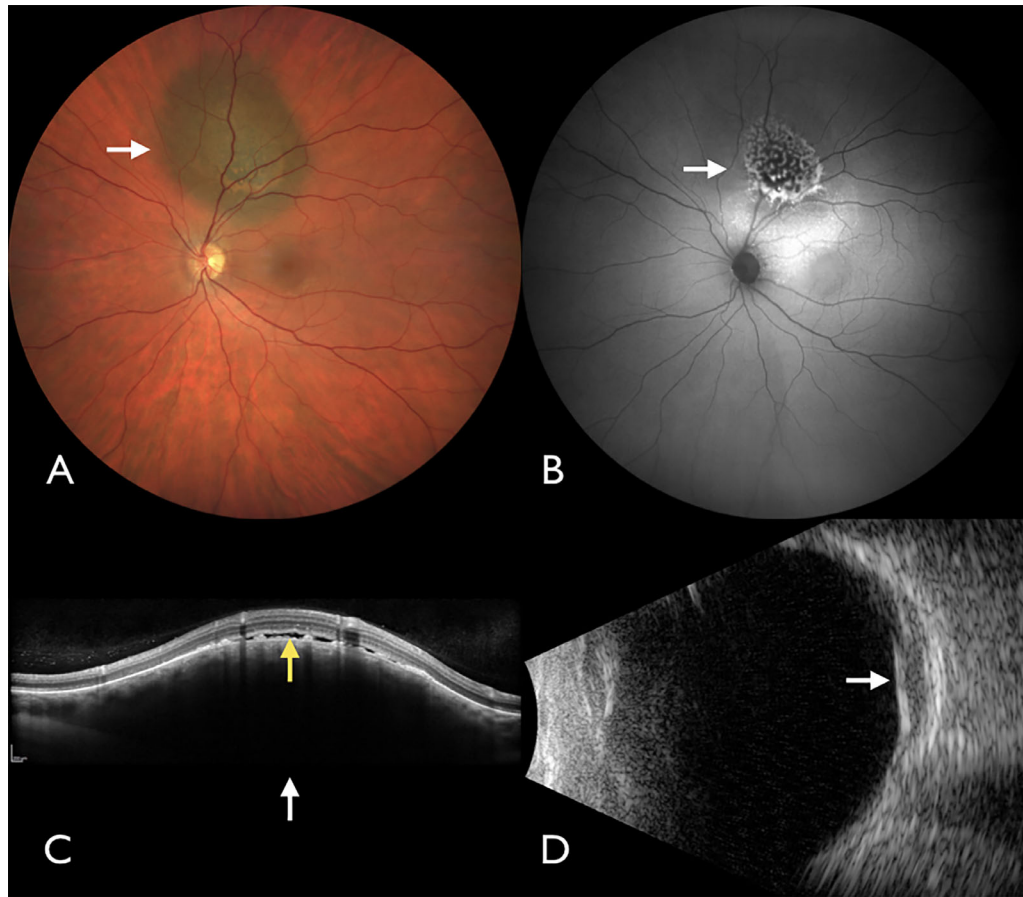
Multimodal imaging of malignant choroidal melanoma. (A) Choroidal melanoma (arrow) with overlying orange pigment. (B) Autofluorescence demonstrating the intense bright signal (arrow) of orange pigment. (C) OCT showing dark melanoma with low signal (white arrow) and overlying subretinal fluid (yellow arrow). (D) Ultrasound examination showing elevated melanoma (arrow) with acoustic hollowness, thickness > 2 mm, and shallow subretinal fluid.
